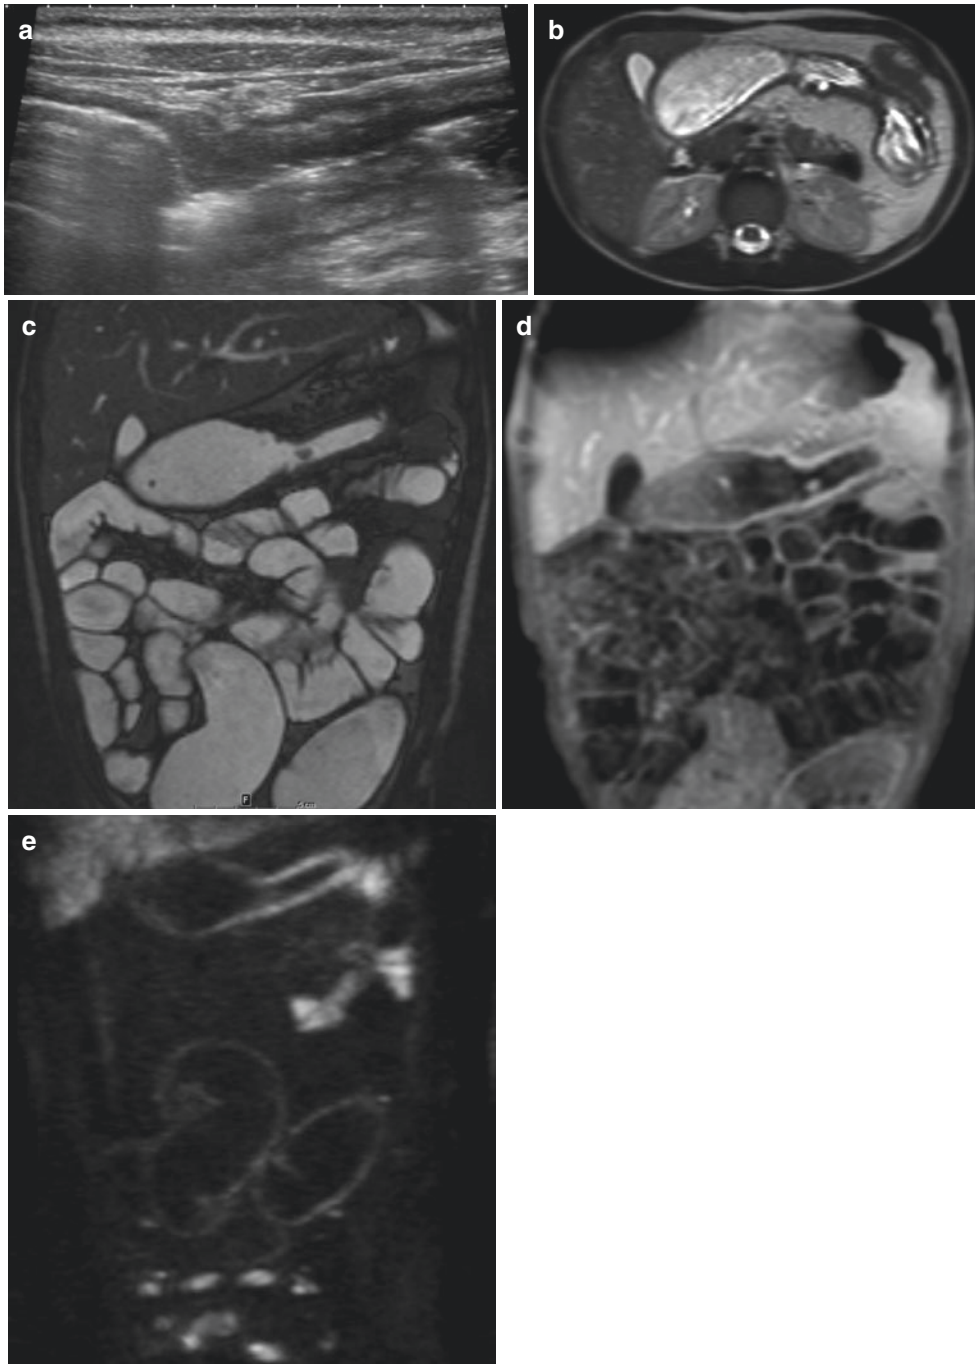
Thirteen-year-old boy with a stenosis of the transverse colon during the evolution of a CD. (a) US scan shows a thickened transverse colon with a persistently compressed lumen. The right part of the transverse colon is largely distended by air and presents a normal bowel wall. (b) Axial T2-weighted single-shot turbo spin-echo (SshSE) sequence demonstrates a thickening of the left part of the transverse colon with two posterior ulcerations. The right part of the transverse colon is largely distended
